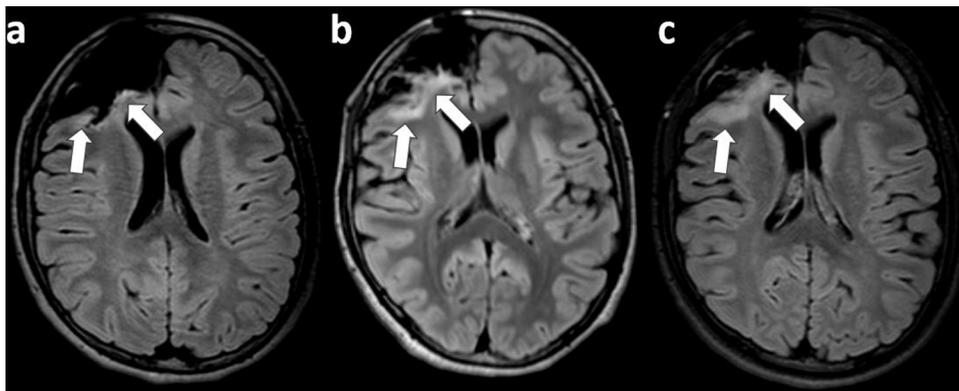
Advancing grade (G0→G1→G2). Patient number 1 from Fig. 2. An 11-year-old boy who underwent resection of FCD in the right frontal lobe. (a) An axial FLAIR image obtained 8 months after surgery shows a thin-linear high-signal lesion at the surgical margin (arrow). (b) On an MR image taken 1 year after surgery, the high-signal lesion have enlarged to a band-like pattern (arrow). (c) On an MR image taken 2 years after surgery, the high-signal lesion has further enlarged (arrow).
